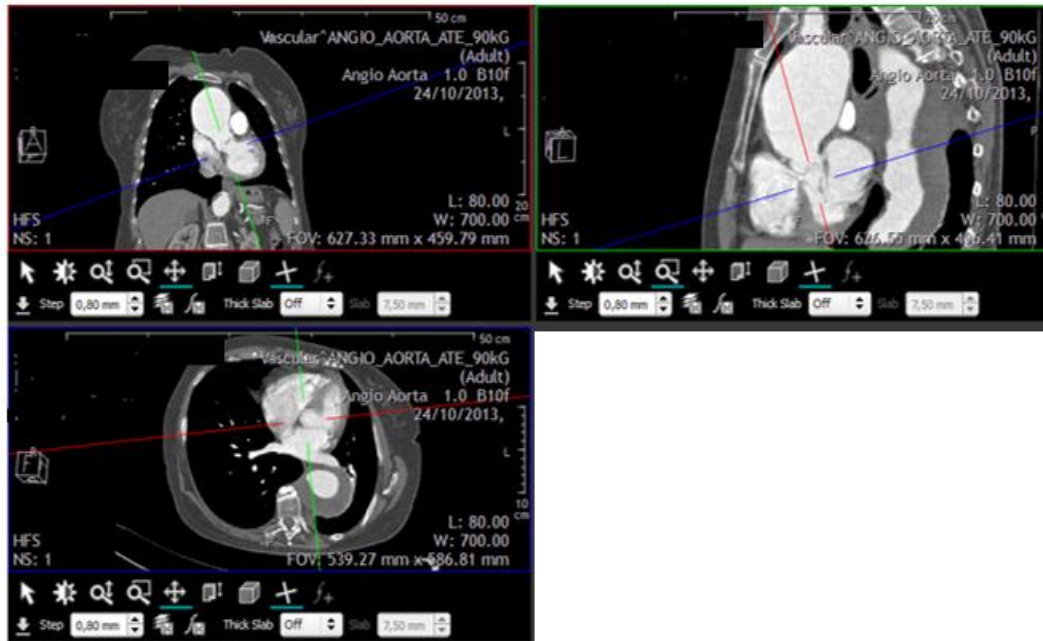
CTA slices views with Synedra View Personal
